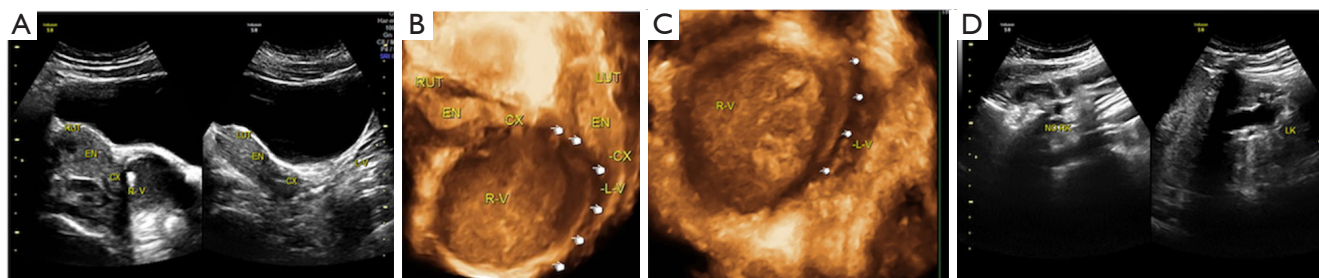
Type I-a UGTOIRA syndrome: U3b-C2-low OVS, complete bicorporal uterus, double cervix without cervical obstruction, with right-low OVS (without communication observed intraoperatively), and right renal agenesis. Sonograms were obtained from a 17-year-old female patient. (A) TAS 2D sagittal pelvic planes demonstrating a normal right uterus, cervix, and a large amount of hematocoele in the posterior space of the OVS (left side of the figure), normal left uterus, cervix, and left vagina (right side of the figure). (B) TAS 3D coronal plane of the demonstrating complete bicorporal uterus, double cervix, and right-low OVS with a large amount of hematocoele in the posterior space of the OVS (the hand arrows indicate the OVS). (C) TAS 3D coronal plane of the vagina under stereoscopy demonstrating the right-low OVS with a large amount of hematocoele in the posterior space of the OVS, without communication (the hand arrows indicate the OVS). (D) TAS 2D sagittal planes identifying the absence of the right kidney (NO RK; left side of the figure) and a normal left kidney (LK; right side of the figure). RUT, right uterus; EN, endometrium; CX, cervix; R-V, right vagina; LUT, left uterus; L-V, left vagina; RK, right kidney; LK, left kidney; UGTOIRA, unilateral genital tract obstruction with ipsilateral renal anomaly; OVS, oblique vaginal septum; TAS, transabdominal sonography; 2D, 2-dimensional; 3D, 3-dimensional.
